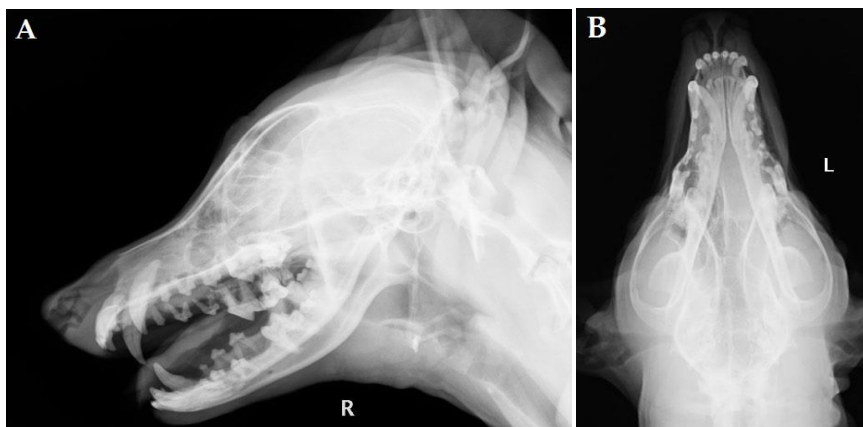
Skull radiographs of the right lateral view (A) and dorsoventral view (B)
